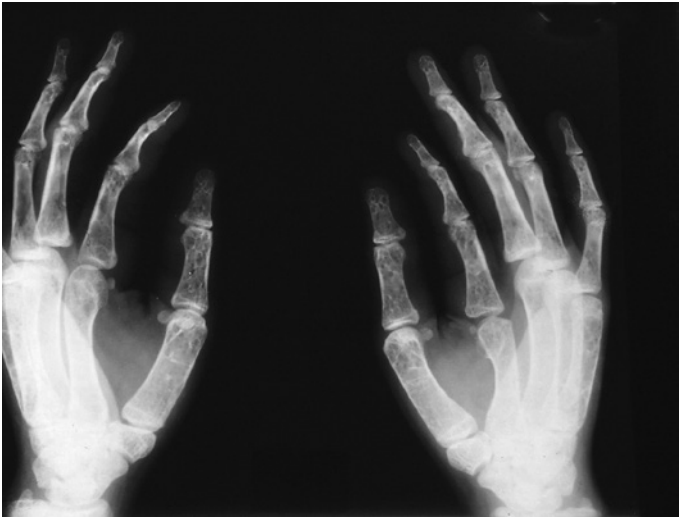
Radiograph of the hands of a patient with β thalassaemia intermedia showing lucent areas that represent expanded erythropoiesis. (With thanks to Dr Saad Abdalla.)
